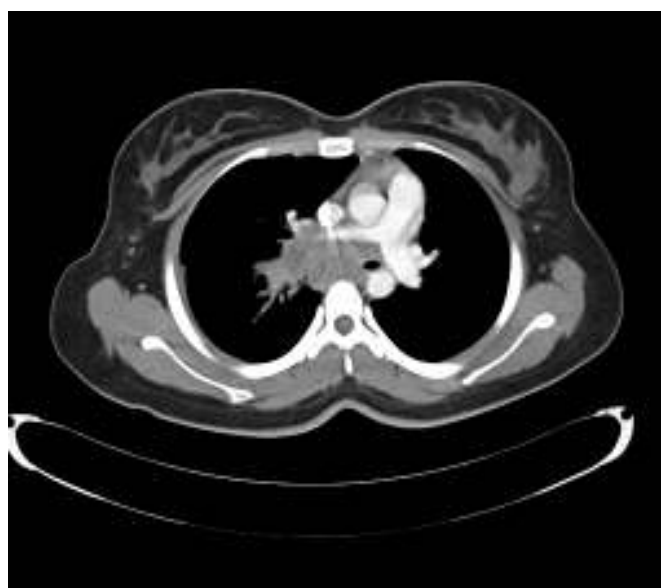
CT Chest mediastinal window showing enlarged sub carinal and right hilar nodes.
